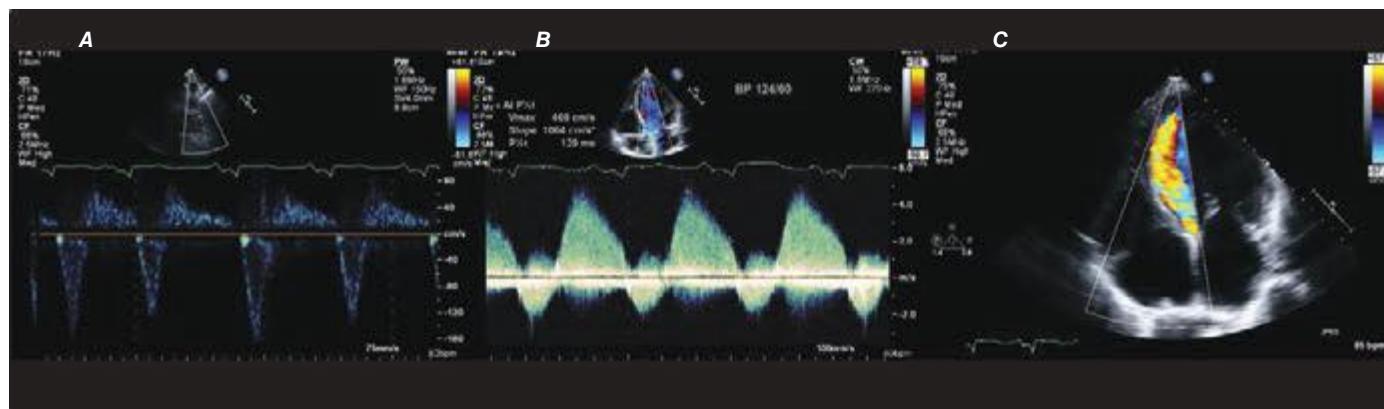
3 Three types of Doppler ultrasound. A and B, Pulsed and continuous wave Doppler waveforms with time on horizontal axis and velocity of blood flow on vertical axis. C, Color flow Doppler, where velocities are encoded by colors according to scale on right side of screen and superimposed on a two-dimensional grayscale image.
